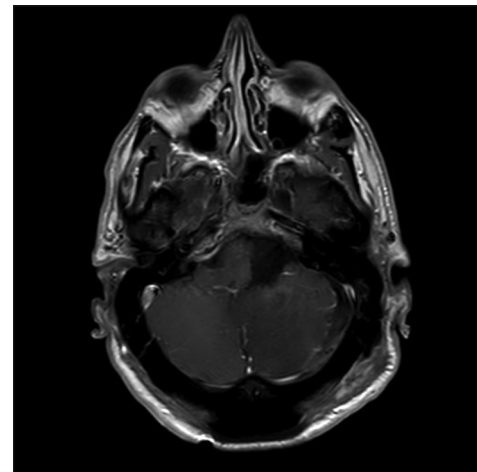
Postoperative post-contrast T1-weighted magnetic resonance imaging (MRI) showing gross total resection.
